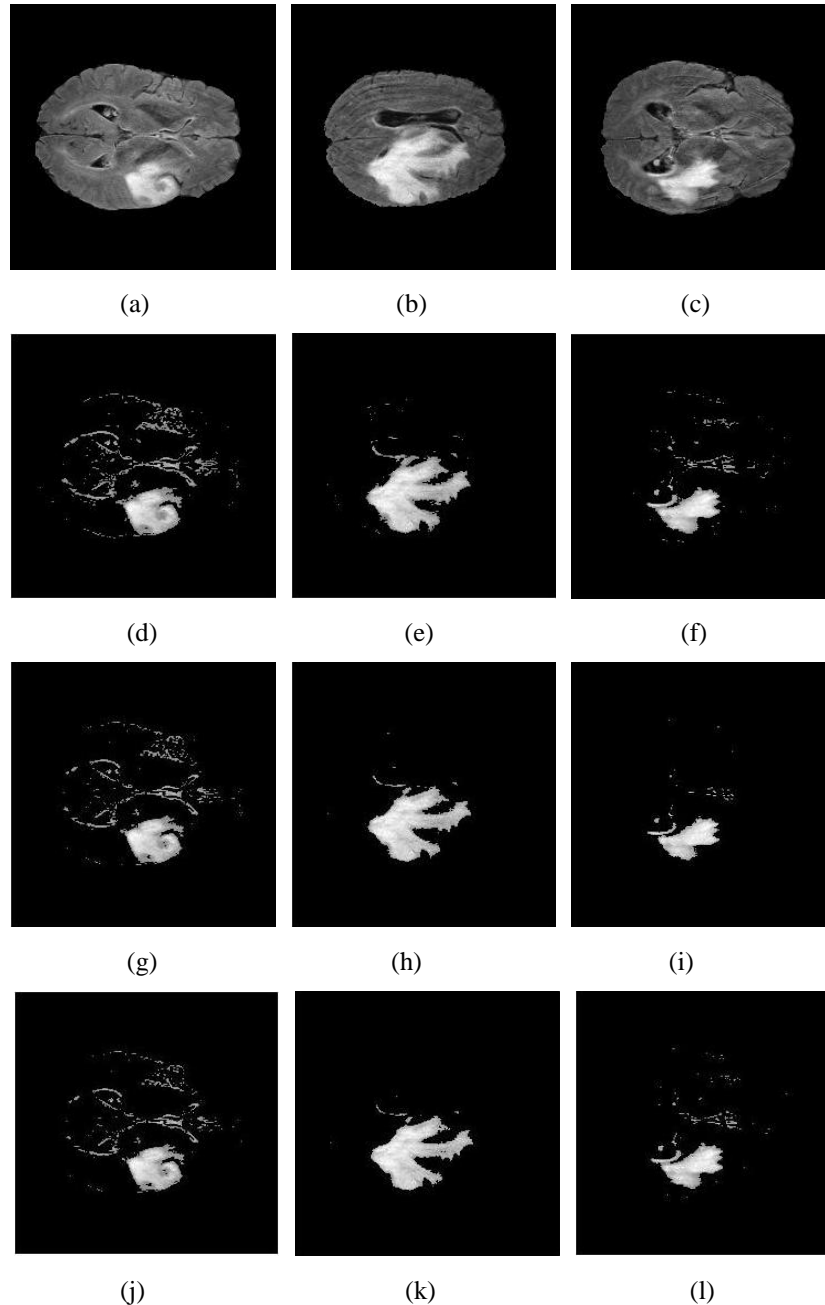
(left to right) (a, b, c): MRI Flair modality brain image obtained from MICCAI dataset; (d, e, f): Segmented output images by proposed CBSS GC segmentation technique; (g, h, i): Segmented output images by proposed KMSS GC segmentation; (j, k, l): Segmented output images by proposed FUZZY GC segmentation
